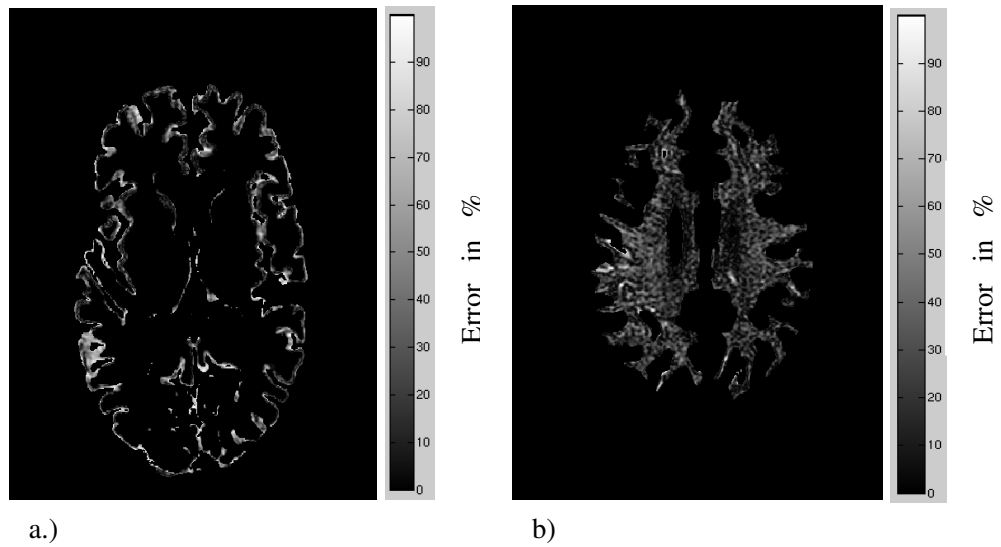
MR images of Grey matter a) and White matter b) absolute percentage error maps in one of our subjects
